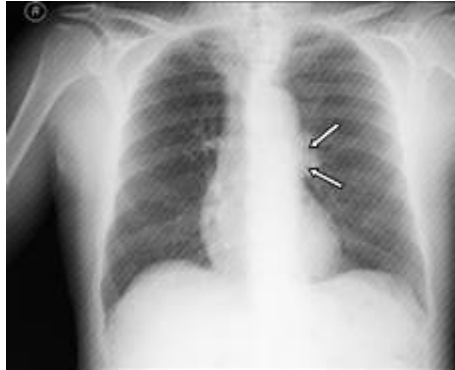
Two mass lesions with ill-defined border adjacent to left pulmonary hilum on PA chest radiography (white dotted arrows).
